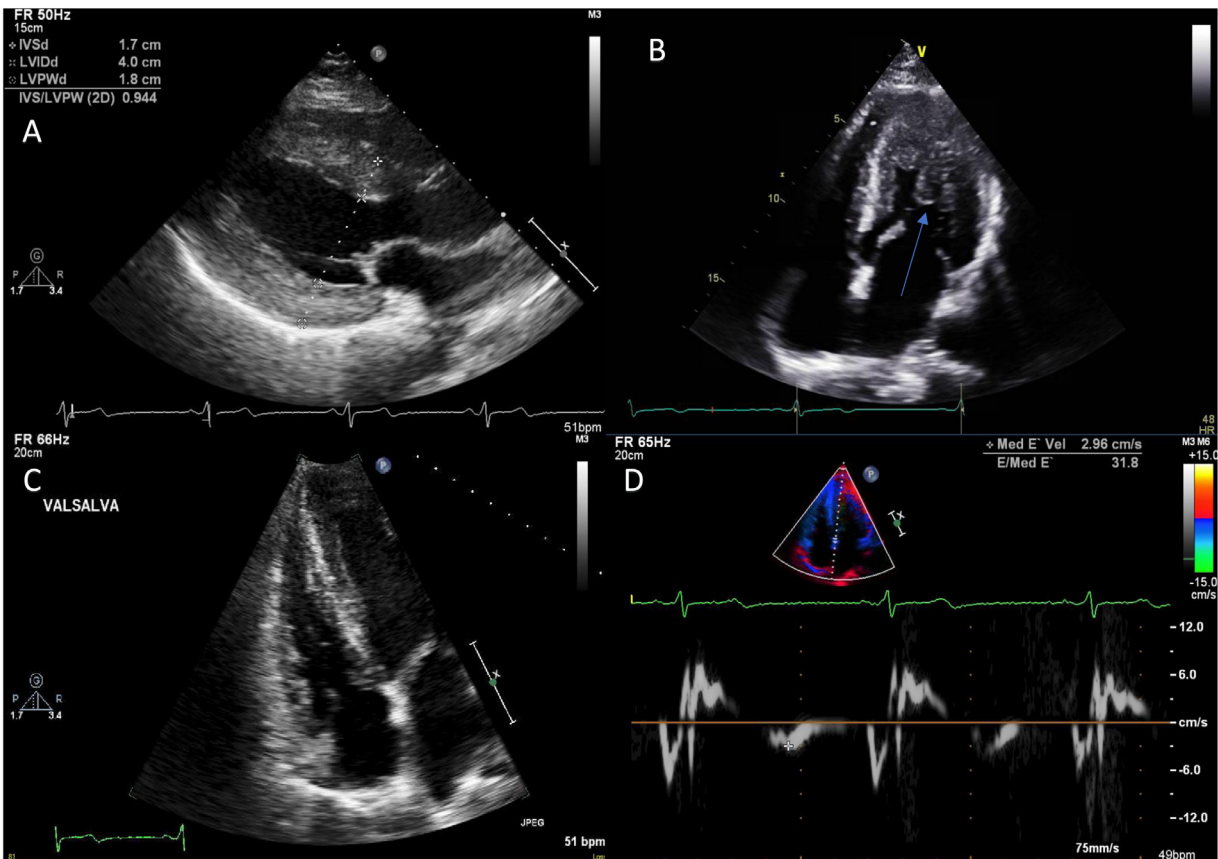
(A) Parasternal long axis at end diastole. Interventricular septal diameter 1.7 cm, Left ventricular posterior wall diameter 1.8 cm. (B) Note hypertrophic papillary muscle (blue arrow). (C) Right ventricular hypertrophy is also present. Biventricular hypertrophy and papillary muscle hypertrophy are both common findings in patients with FD.¹³ (D) Diastolic dysfunction is common.¹³ Medial E' velocity on tissue Doppler is severely reduced to 2.65 cm/s.
